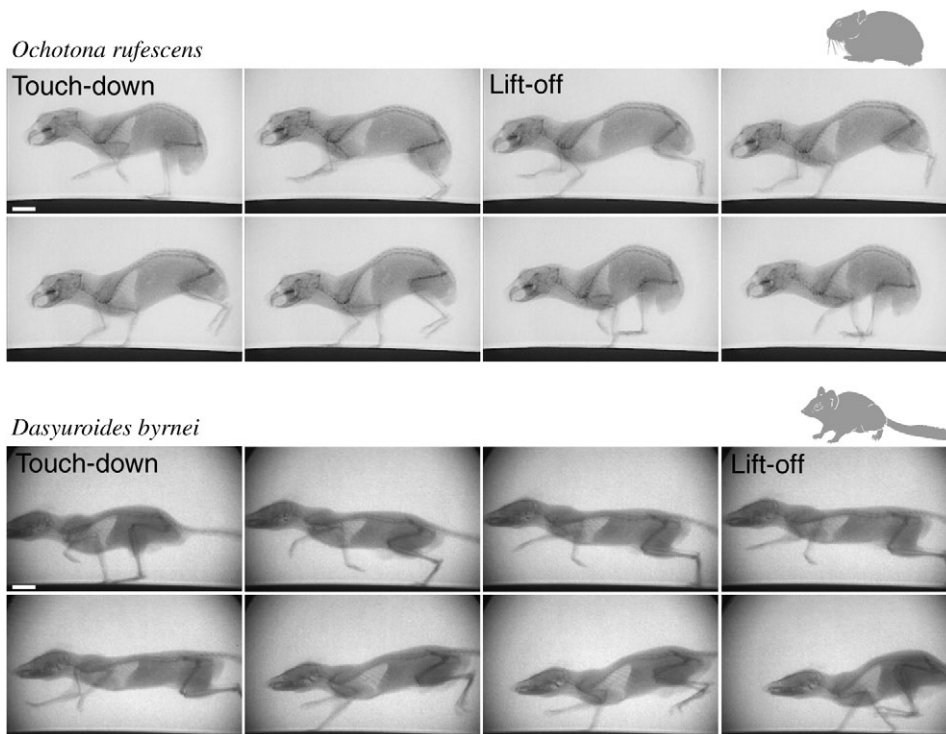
X-ray sequences of the 'tailless' pika *Ochotona rufescens* during gallop (1.16 m s^{-1}) and the long-tailed kowari *Dasyuroides byrnei* during half-bound (0.92 m s^{-1}). Scale bars, 20 mm.
